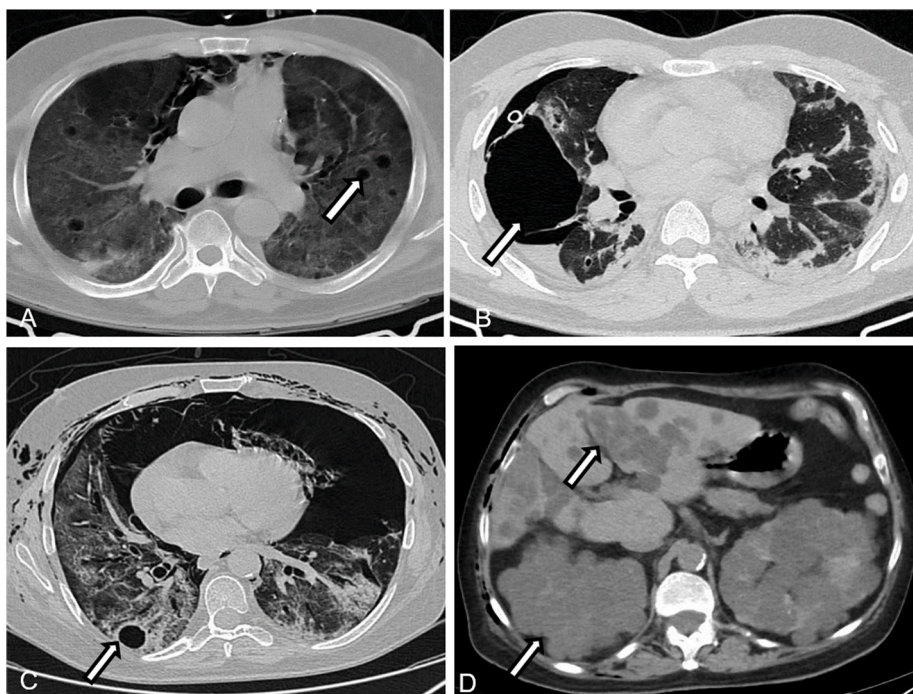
Cystic lung pathologies in COVID-19 patients predisposing to pneumomediastinum. A: Axial CT image in lung window showing the presence of multiple small lung parenchymal cysts (marked by white arrow). B: Axial CT image in lung window showing the presence of an emphysematous bulla in the right lower lobe (marked by white arrow). C, D: Case of Autosomal dominant polycystic kidney disease showing C: Presence of lung cysts in axial CT image in lung window (marked by white arrow). D: Multiple hepatic and renal cysts in axial CT image in soft tissue window (marked by white arrow).
